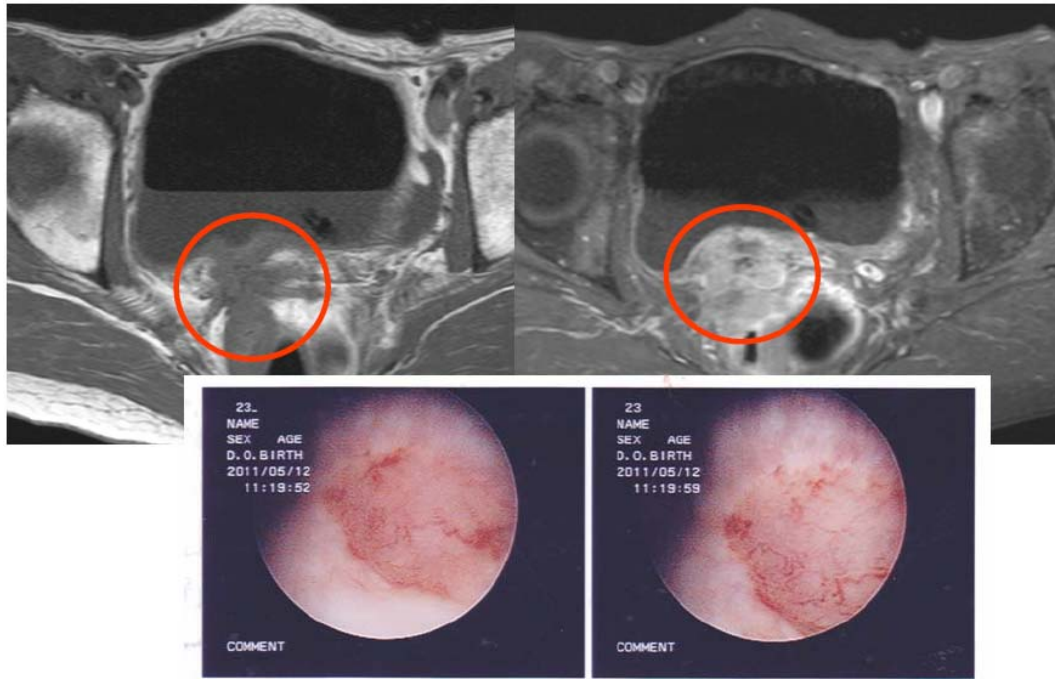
Magnetic resonance imaging showed bladder invasion of the recurrent lesion (left, plain; right, enhanced). Cystoscopic findings revealed the depressed lesion with dilated vessels.
